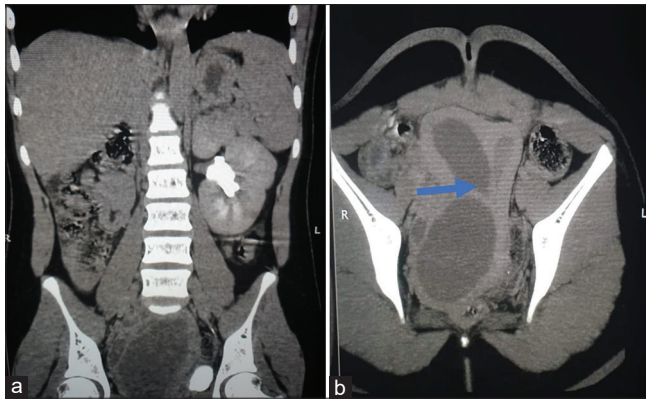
Computed tomography scan of the urinary tract. (a) Right renal agenesis with normal left kidney. Didelphic configuration of the uterus, with fluid seen in the endometrial cavity on both sides. The arrow on (b) shows the nonresorbed uterovaginal septum
